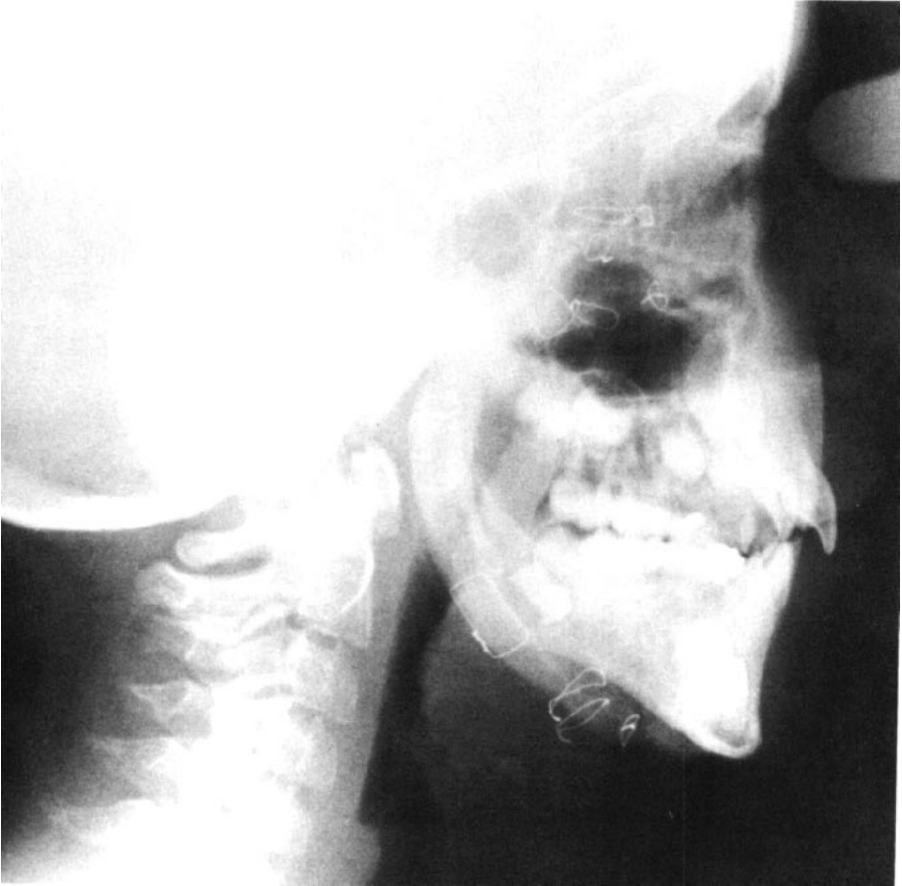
Postoperative lateral radiograph
